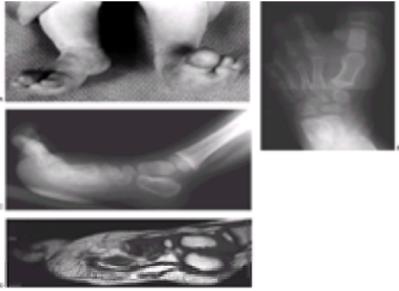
Two-and-a-half-year-old girl with progressive macrodactyly of both feet with macrodystrophia-lipomatosa. A: There is significant plantar hypertrophy, resulting in hyperextension of the digits, and there is marked asymmetry in the digital enlargement. B, C: The plain radiographs demonstrate the soft tissue enlargement, as well as the underlying bony enlargement. D: The MRI demonstrates overgrowth of essentially all elements in the digit, particularly the fibroadipose tissue typically seen in macrodystrophia-lipomatosa.
